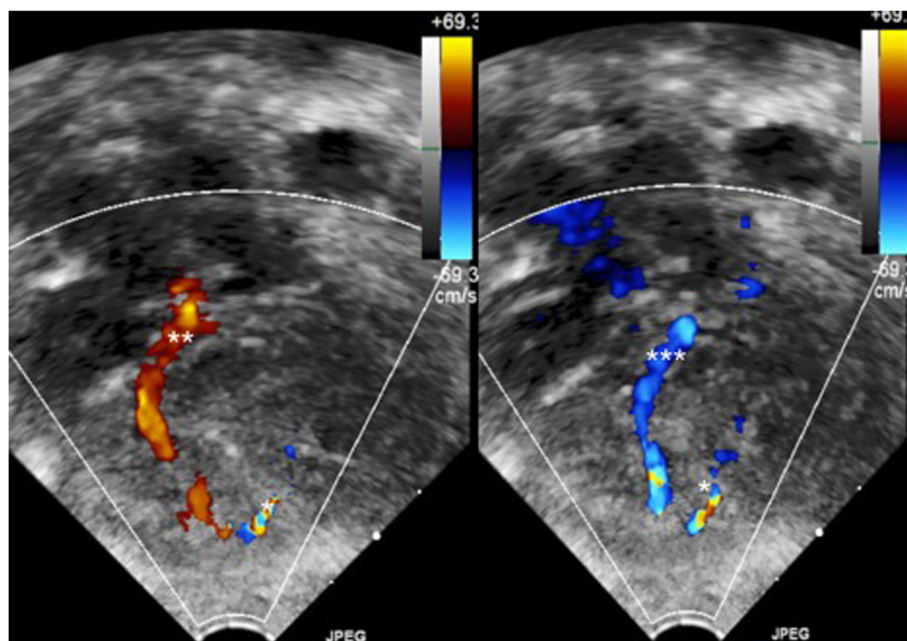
Echocardiographic images of Apical 4 chamber view showing VSD with right to left shunt (*) , prominent coronary artery () and prominent coronary vein (*)
